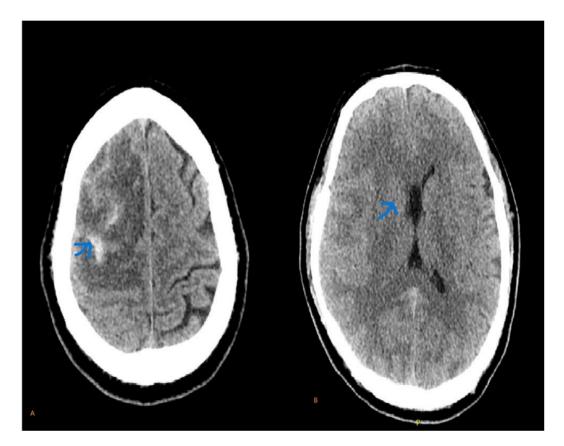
CT scan Brain Plan Axial View (A, B)
